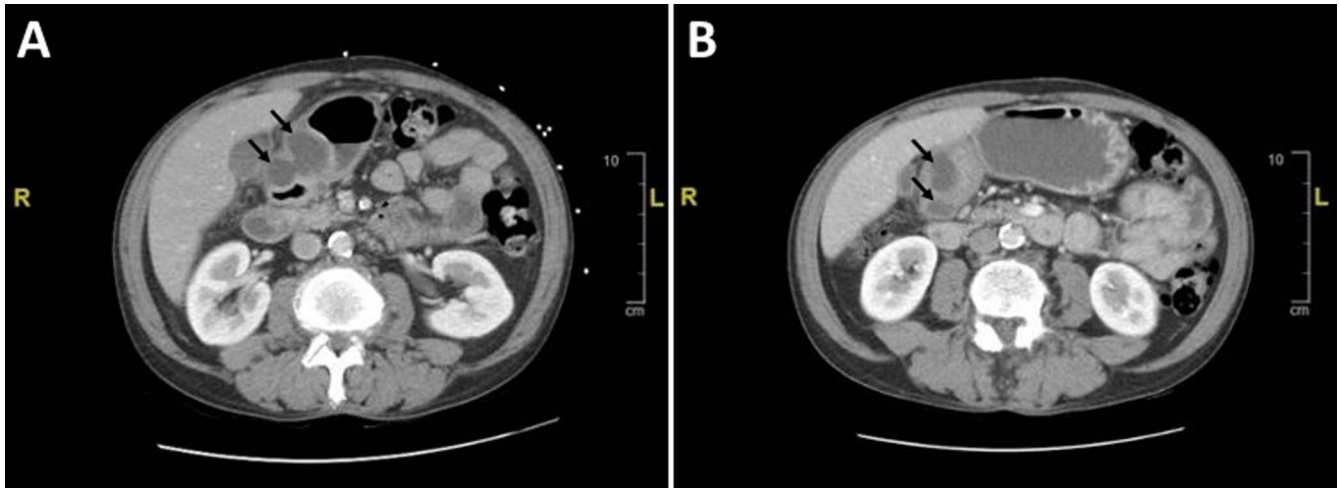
Abdominal and pelvic computed tomography from (A) initial presentation, showing a multiloculated cystic mass (noted by arrows) and thickening of the gastric antral wall. (B) Preoperative imaging 10 weeks later showing progression of the mass with 2 distinct cystic components (noted by arrows), gastric wall edema, and evidence of mass effect with a distended, fluid-filled stomach indicating gastric outlet obstruction.
